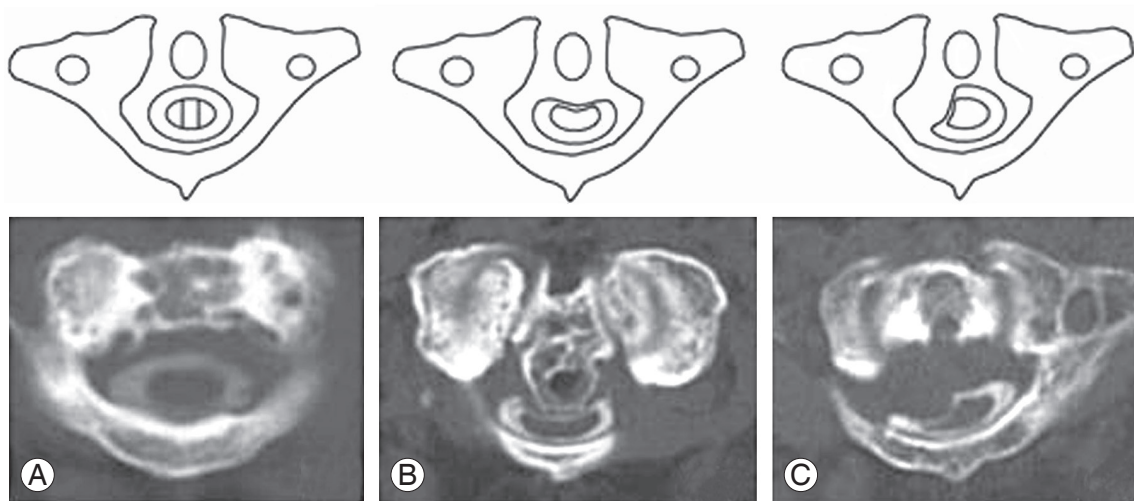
Computed tomography-myelography images. Image at the C1–2 level (A). The transverse diameters of the compression sites were divided into thirds and classified as center type (B) or exterior type (C).
